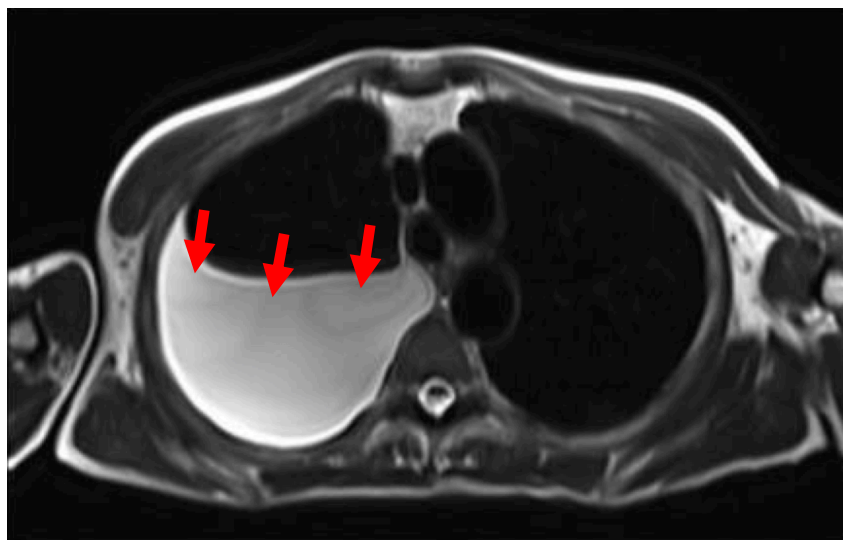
T2-weighted axial image of a patient with a right pleural effusion (indicated by arrows), taken pre-contrast using a 3T Siemens Magnetom PRISMA® MR scanner at the Glasgow Clinical Research Imaging Facility, QEUH
